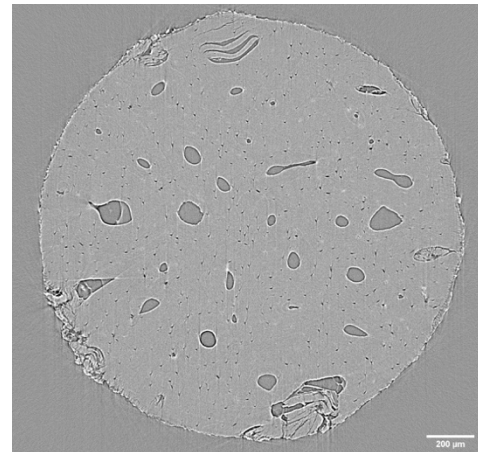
Example of SR μ CT single projection from cortical bone with a cylindrical VOI.
